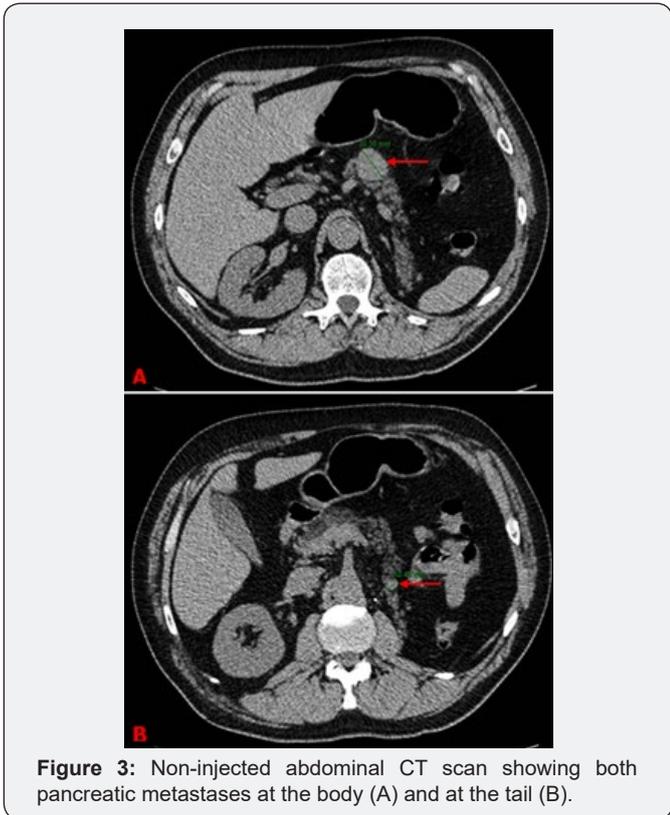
Non-injected abdominal CT scan showing both pancreatic metastases at the body (A) and at the tail (B).
